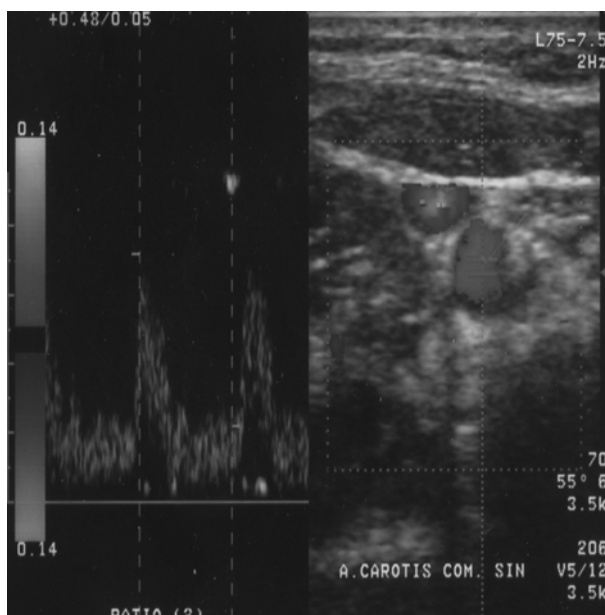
Color Doppler ultrasonography of left CCA.
